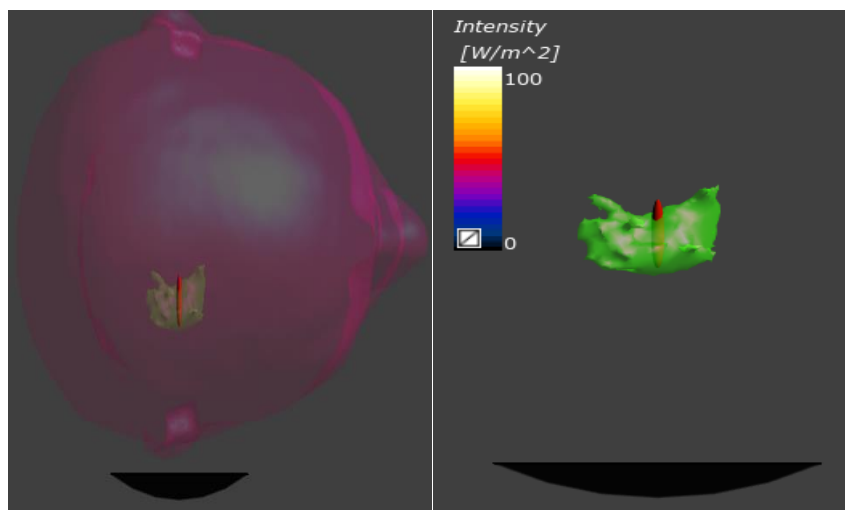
Ultrasound propagation with optimisation transducer and volume intersection between beam and hippocampus (red: beam profile, green: hippocampus).
